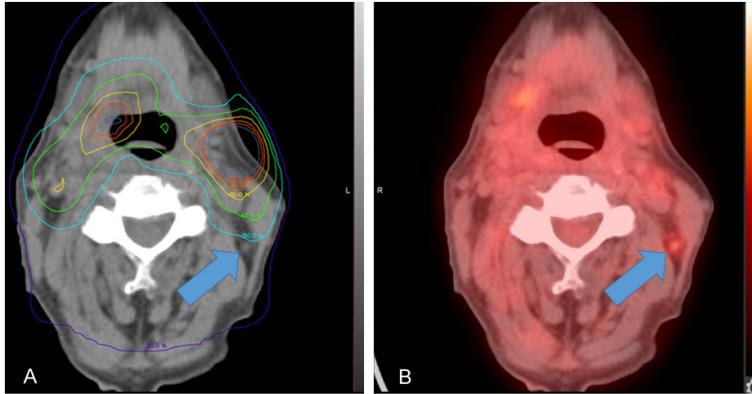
On the left (A) is the treatment planning CT which shows a small posterior left cervical lymph node just outside the 50% isodose curve. On the right (B) is the follow-up FDG PET/CT showing low level activity within this node.
